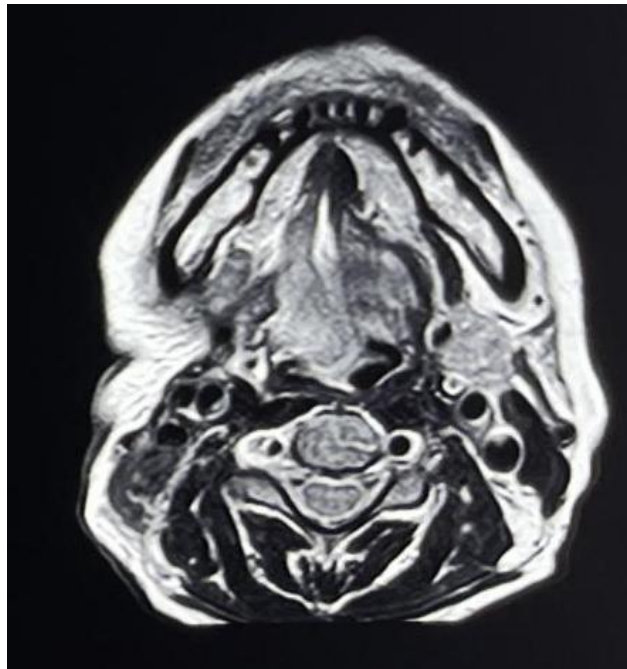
D: MRI T2 sections showing post operative changes
